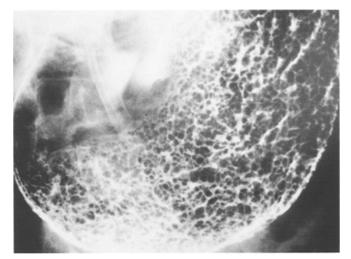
Double-contrast radiograph of patient 2 shows numerous polyps restricted to the fundus and body of her stomach, but not in the cardia, antrum, pylorus and duodenum
